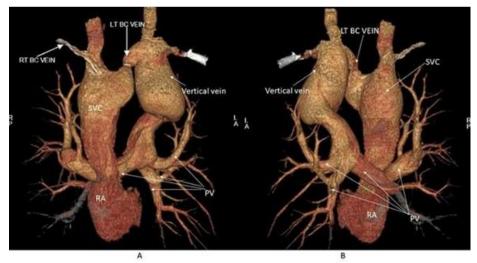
Volume rendering from a helical thoracic CT angiographyscan show anterior (A) & posterior (B) views of all the 4 pulmonary veins (PV) uniting to form Left ascending vertical vein (innominate vein) which is joining the left brachiocephalic vein. The left brachiocephalic vein (BC vein) is draining into the superior vena cava (SVC) which is finally draining into the (RA) right atrium. The left vertical vein and superior vena cava (SVC) appear grossly dilated.
